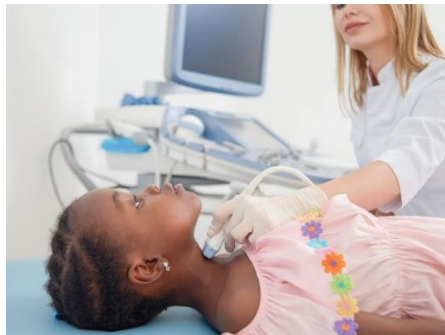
Putting the ultrasound machine onto your neck to measure your windpipe (1)
